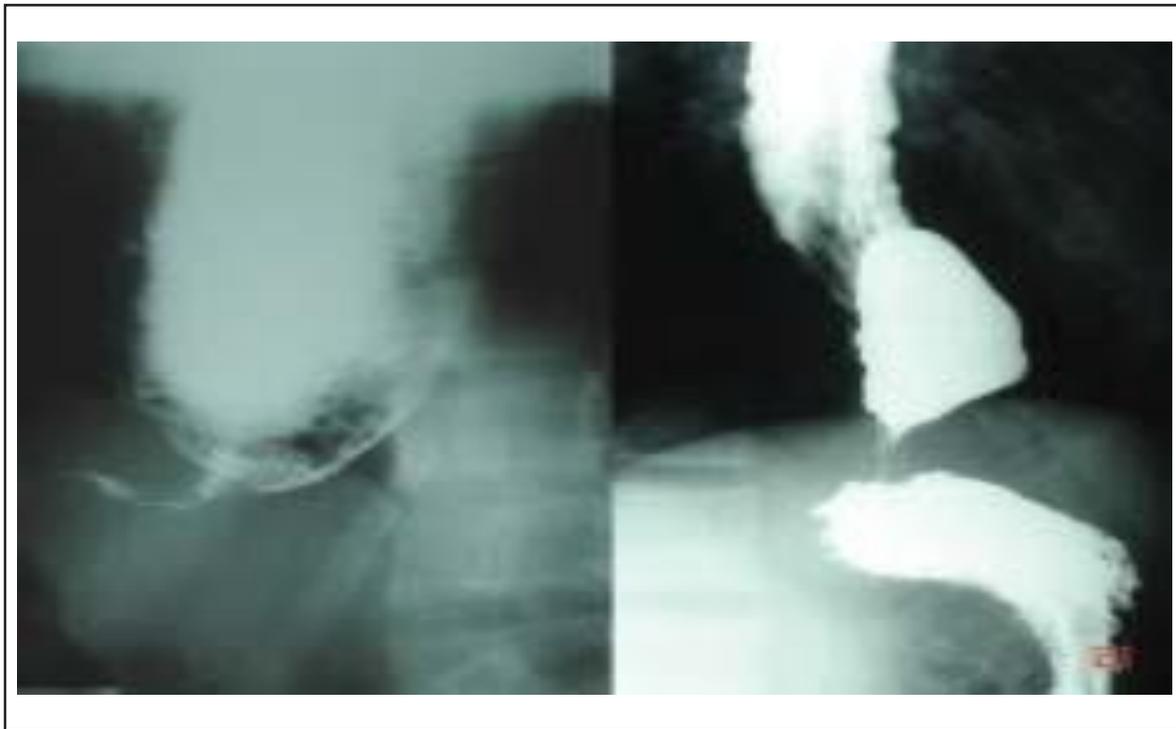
X-ray pictures showing the details of barium swallow study. (A) Classic “bird beak” tapering deformity of the oesophagus in achalasia cardia before dilatation & (B) post-dilatation study showing thin streak of barium in LES region” (same patient).
